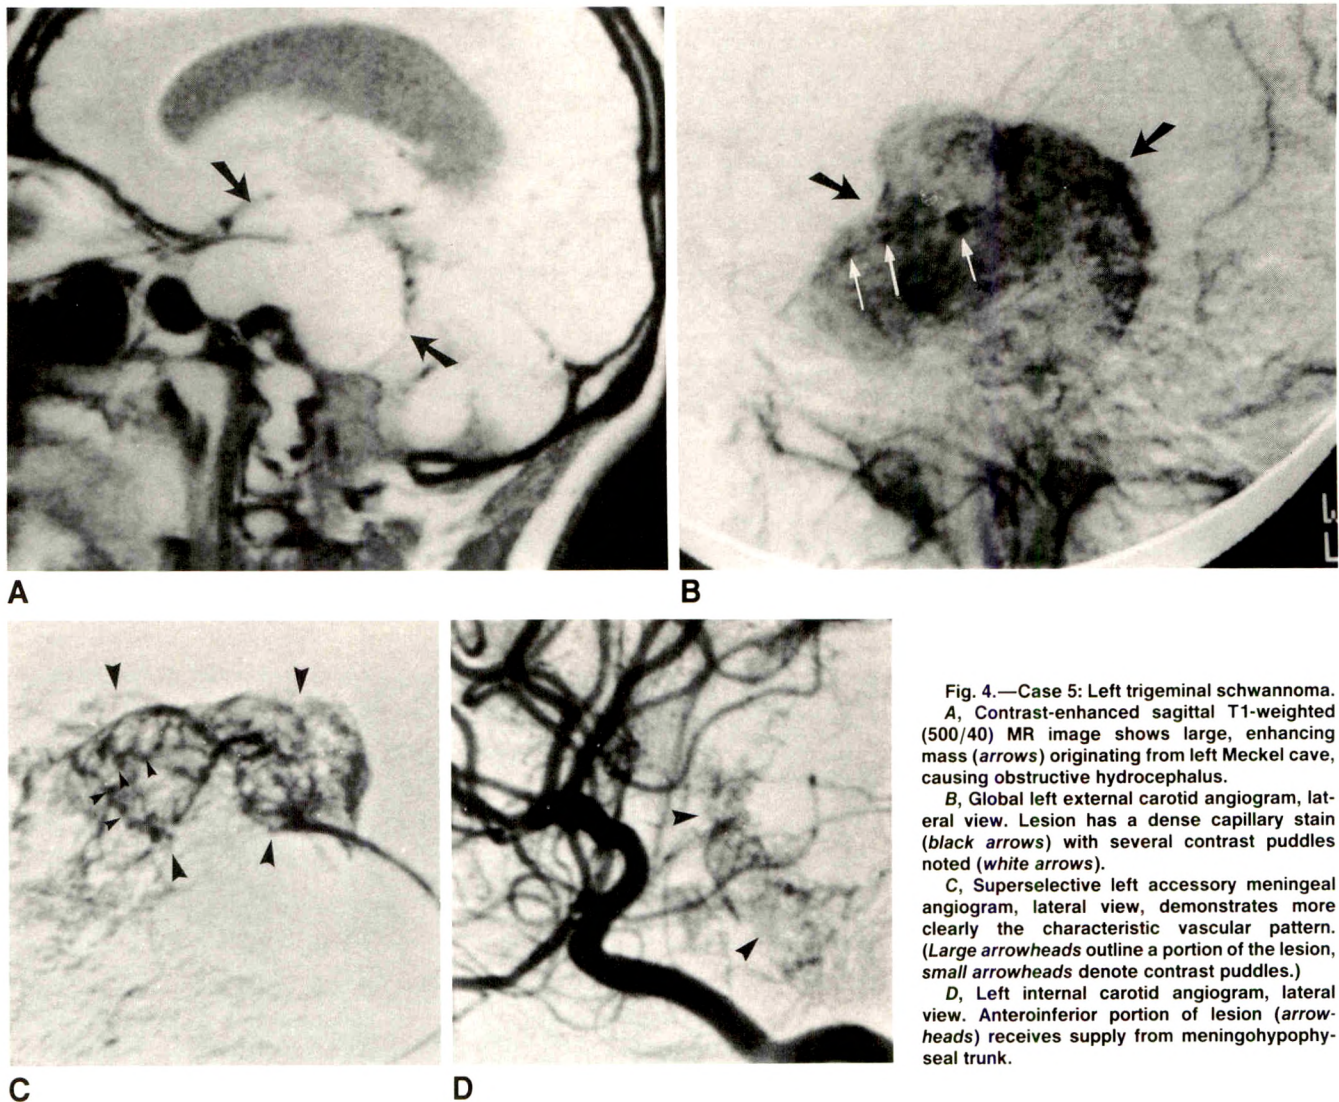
Case 5: Left trigeminal schwannoma. A, Contrast-enhanced sagittal T1-weighted (500/40) MR image shows large, enhancing mass (arrows) originating from left Meckel cave, causing obstructive hydrocephalus.
